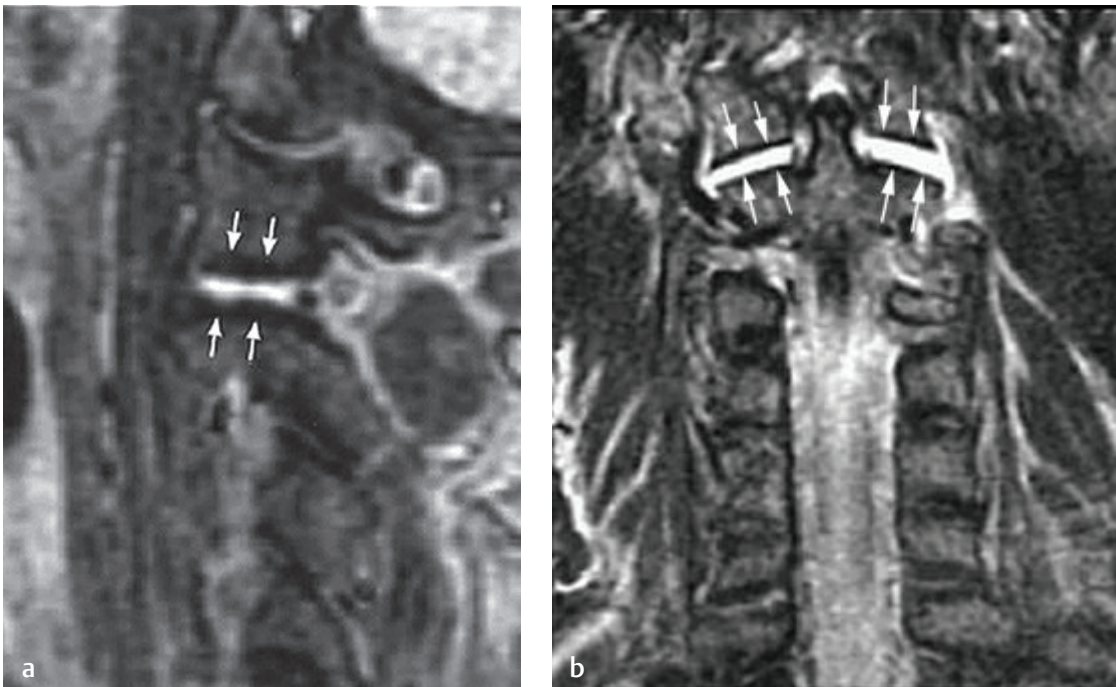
These (a) sagittal T2-weighted and (b) coronal T2-weighted images of atlantoaxial dissociation show edema and distraction (arrows on each) through the C1-C2 joint.
